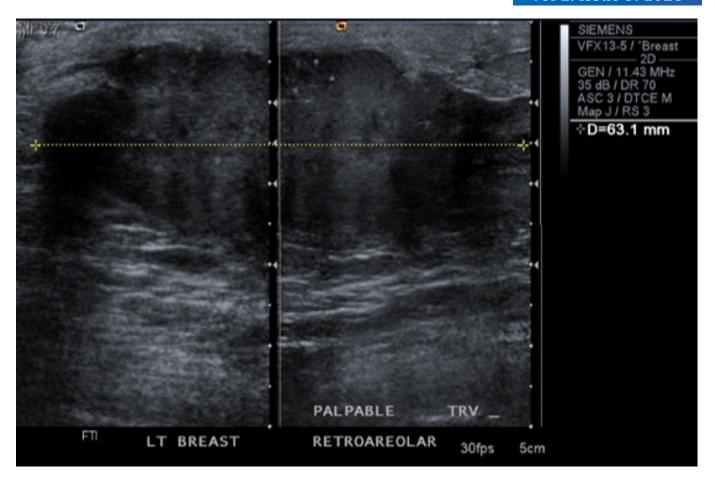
Ultrasound, Left Breast
